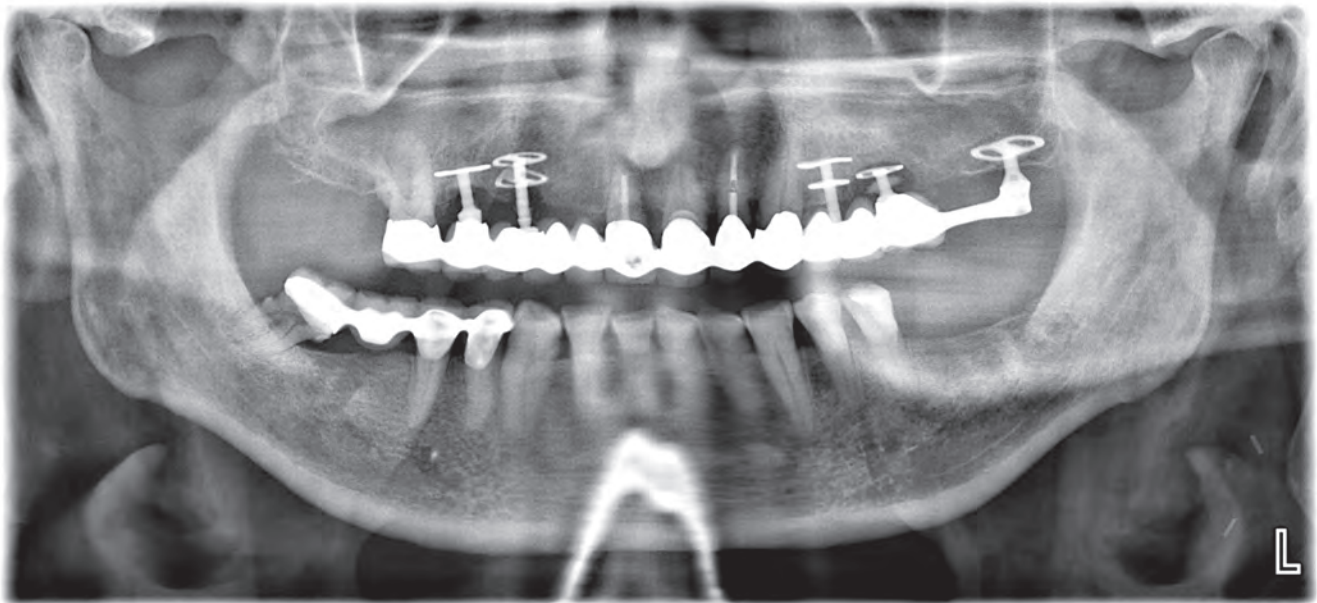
Panoramic radiograph showing the implants and the upper jaw bridge prior to removal of the implant in region 25. This implant had been selected with a vertical shaft that was too short. The inadequate length resulted in bone necrosis adjacent to the first (basal) cortical plate. The implant was removed in 2024 from underneath the existing bridge without damaging the prosthesis.
